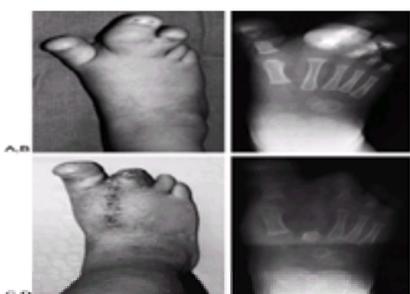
A: Second ray macroductyly with some enlargement of the hallux and third toe. B: Radiographic appearance. C: Clinical appearance after second ray resection and third toe interphalangeal disarticulation. D: Radiographic appearance 1 year later.
